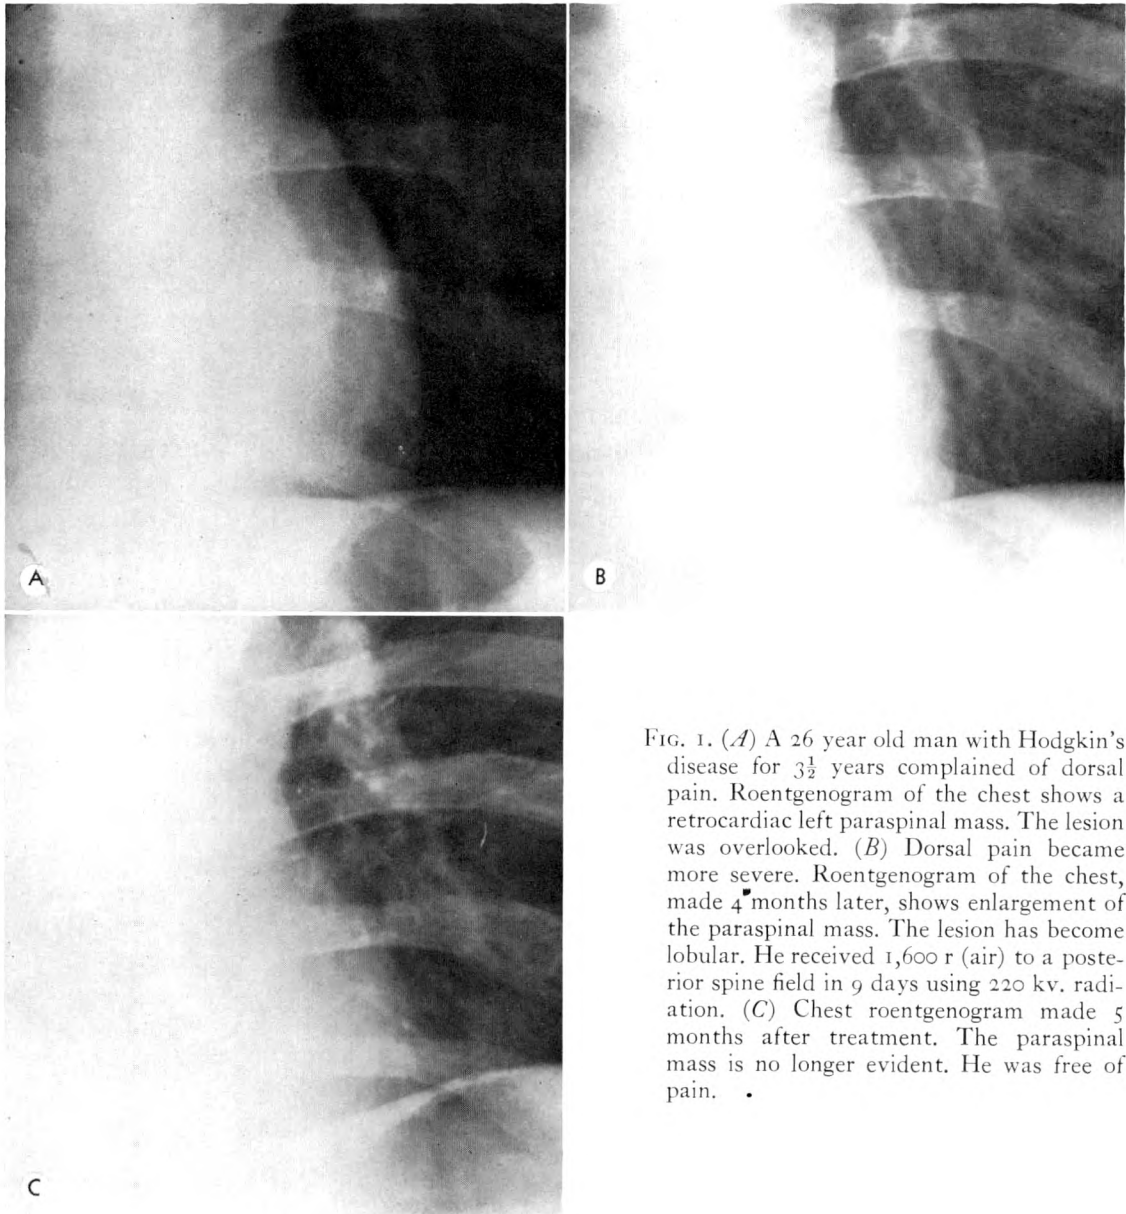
(A) A 26 year old man with Hodgkin's disease for  $3\frac{1}{2}$  years complained of dorsal pain. Roentgenogram of the chest shows a retrocardiac left paraspinal mass. The lesion was overlooked. (B) Dorsal pain became more severe. Roentgenogram of the chest, made 4 months later, shows enlargement of the paraspinal mass. The lesion has become lobular. He received 1,600 r (air) to a posterior spine field in 9 days using 220 kv. radiation. (C) Chest roentgenogram made 5 months after treatment. The paraspinal mass is no longer evident. He was free of pain.
